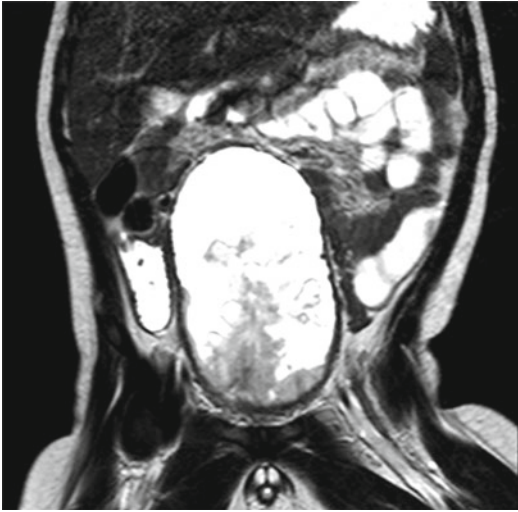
Magnetic resonance imaging of a 2-year-old patient with an embryonal rhabdomyosarcoma of the bladder: the tumor grew intraluminally to completely fill the organ
